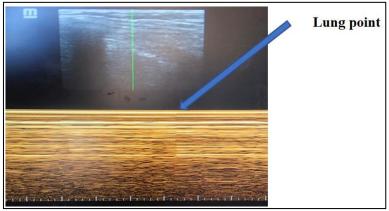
Pleural ultrasound showing a bar-code appearance
